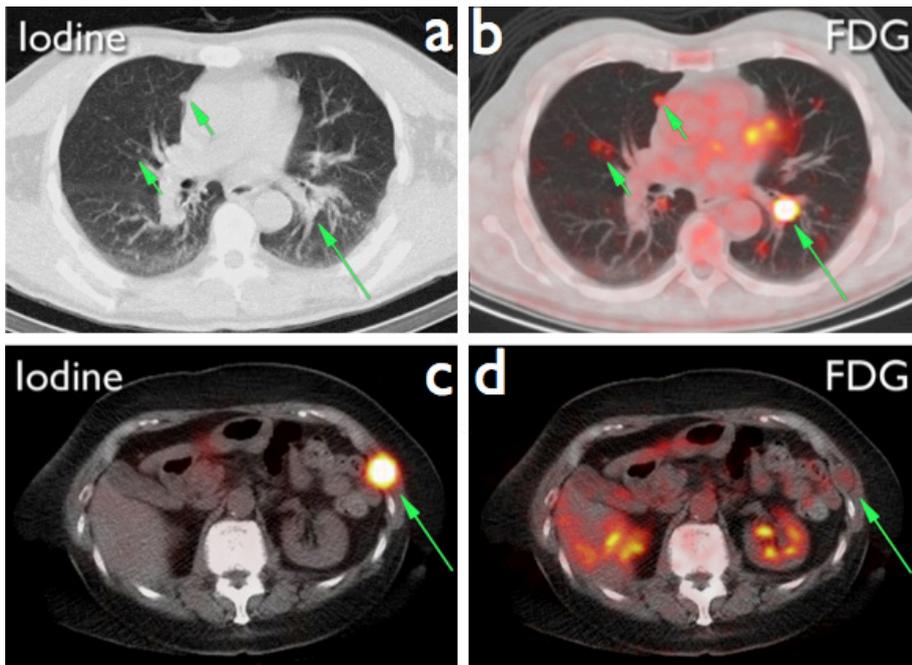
Images from two different patients scanned with both ^{124}I and ^{18}F -FDG PET/CT. The ^{124}I PET/CT of patient 1 (1a) shows multiple ^{124}I negative pulmonary nodules, which are evidently ^{18}F -FDG positive (1b). The thoracic wall lesion of patient 2 is clearly ^{124}I avid (1c) and showing no uptake on the FDG-PET/CT.
